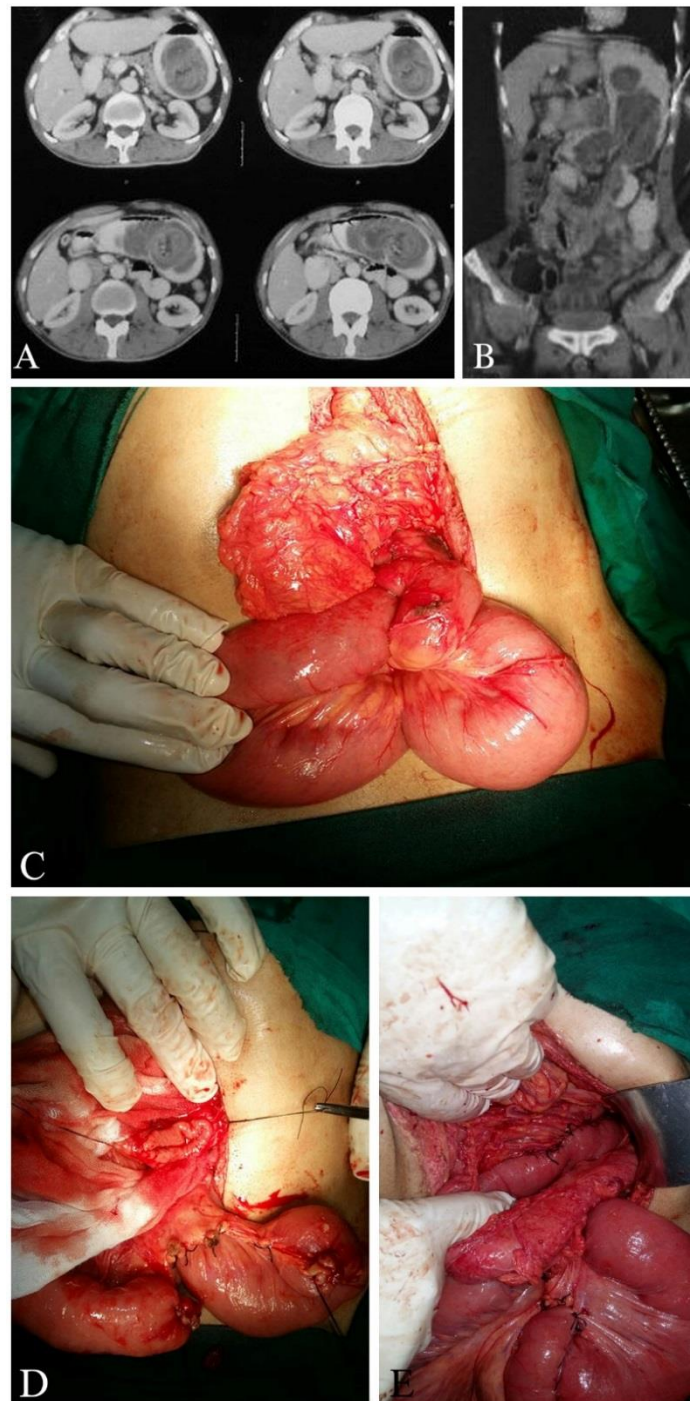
A. CT axial section of jejunogastric intussusception
